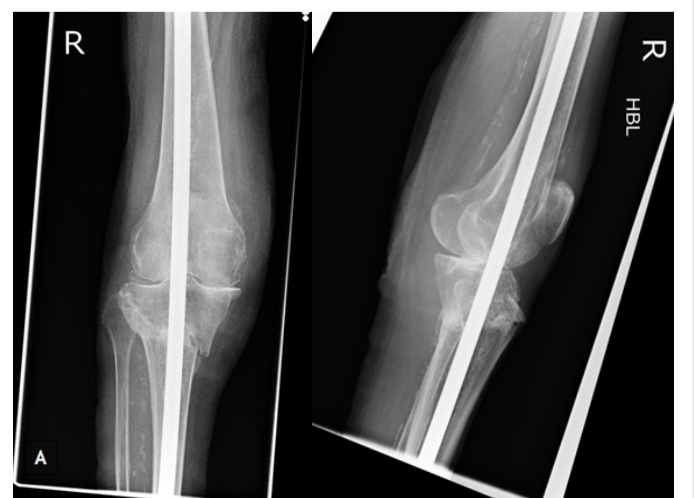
16-week post-operative radiograph showing good fracture union and no secondary displacement. (a) Anteroposterior view, (b) lateral view.
